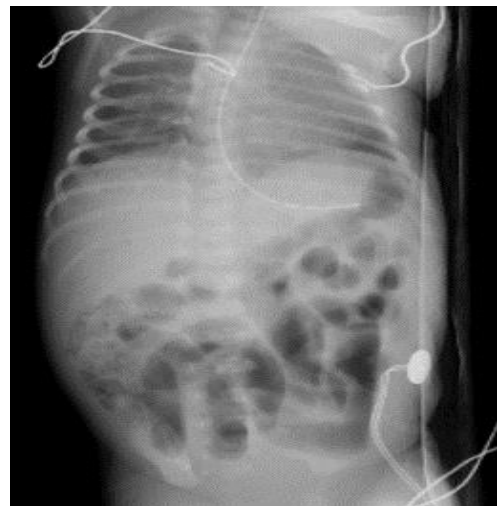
The X-ray reveals the appearance of NEC.
